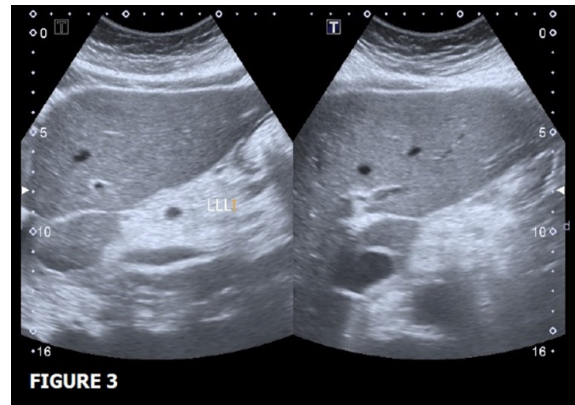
Ultrasound scan of the hepato-biliary system shows mild hepatomegaly.
